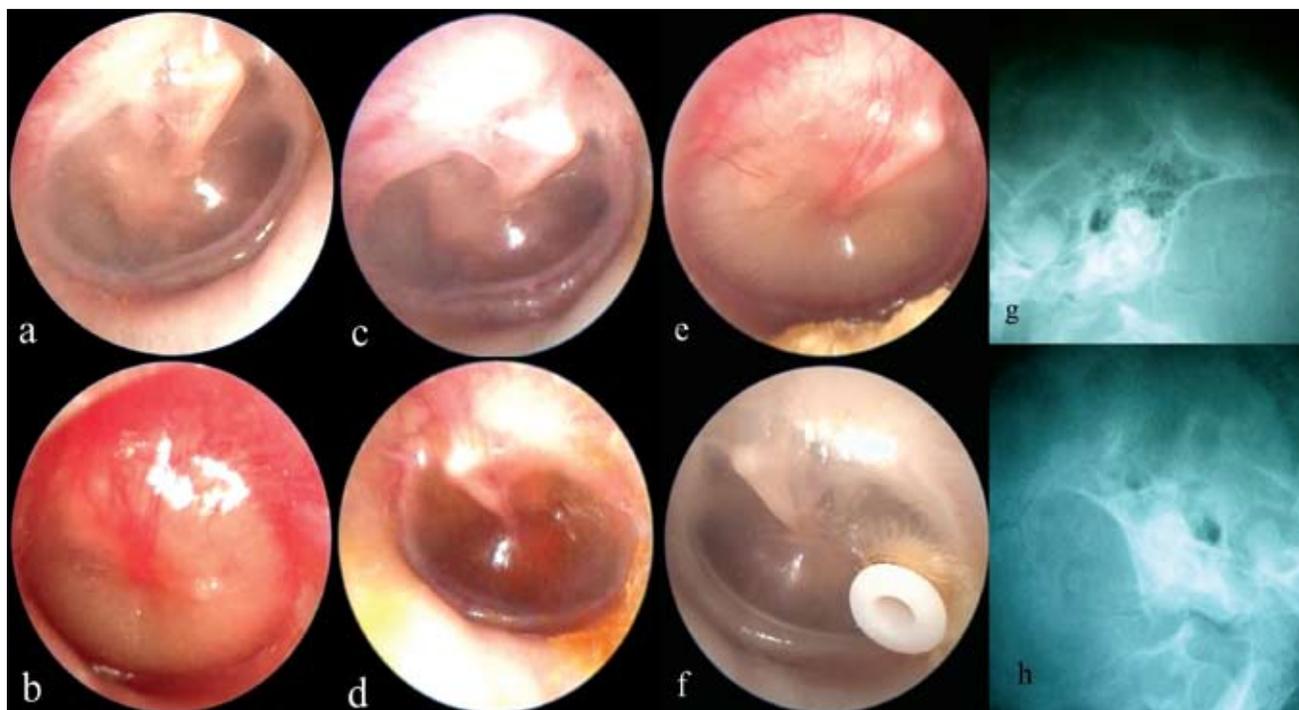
Evolution of a 4y2m child diagnosed with adenoid hypertrophy, with left acute suppurative otitis media and history of repeated otitis media with effusion of the left ear who underwent adenoidectomy and tympanotomy with ear ventilation tube fixation on the left ear. First visit (Figures a-b): a) Right ear-normal tympanic membrane, b) Left ear - acute otitis media, pre-perforative stage. After 1 month (preoperative, figures c-d): c) Right ear-normal tympanic membrane, d) Left ear - otitis media with effusion - through the transparency of the relatively aspired tympanic membrane can be seen a brown-yellowish liquid that fills the whole cavum tympani. 3 months after adenoidectomy and ear ventilation tube fixation on the left ear, in an acute URI (Figures e-f): e) Right ear - acute otitis media with effusion - through the transparency of the tympanic membrane can be seen a serous liquid that fills the whole cavum tympani with a tendency to become purulent, f) Left ear - normal tympanic membrane with ear ventilation tube efficient in the postero-inferior quadrant; no secretion are visible through the transparency of the tympanic membrane nor in the external auditory canal; Figures g-h - Schüller's incidence X-ray of the mastoid bones made at the first visit (equivalent of figures a-b) : g) Right ear - moderate pneumatization of the mastoid air cells, h) Left ear - poor pneumatization and cloudiness of the mastoid air cells (personal library⁽²⁷⁾)
